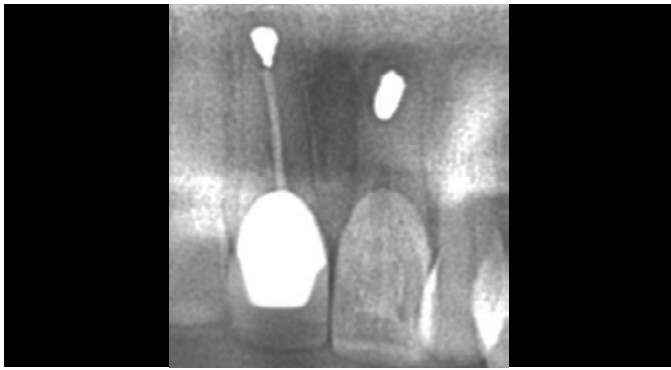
Radiograph received from referring GDP
